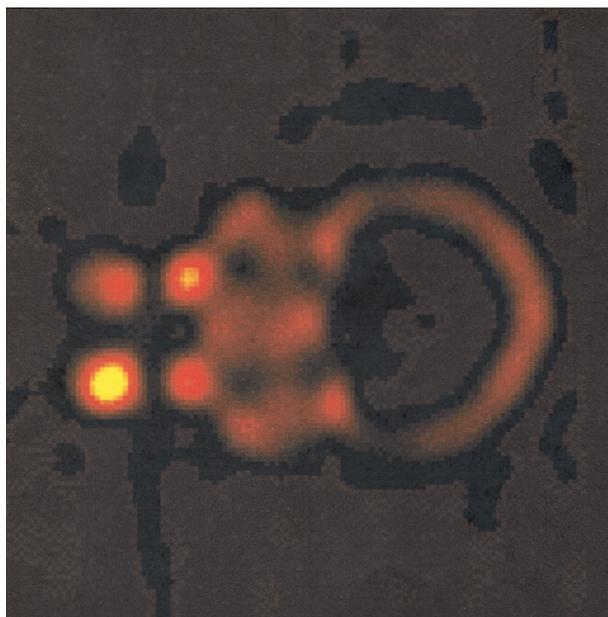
Bone-specific uptake including left mandible lesion after 6 mCi/kg of  $^{153}\text{Sm}$ -EDTMP. Dosimetry indicated that the solitary osteoblastic lesion in the mandible received approximately 220 Gy. Single photon emission computed tomography imaging at 24 hours after  $^{153}\text{Sm}$ -EDTMP administration.
